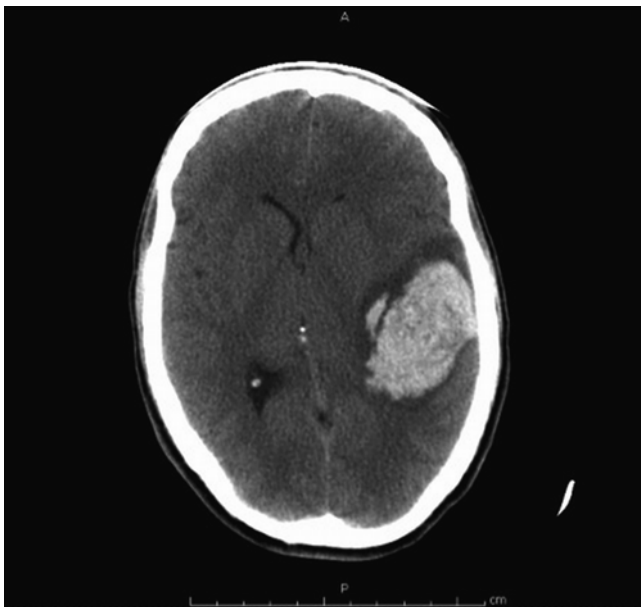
Non-contrast axial CT of brain showing a large intracerebral hemorrhage at time of presentation
